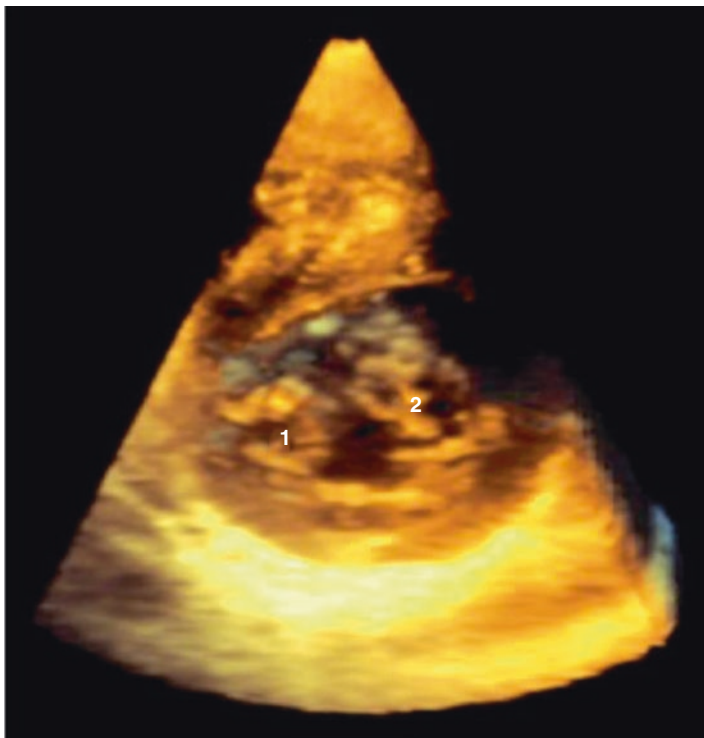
Parasternal short axis of 3D echocardiogram image from a patient with a transitional atrioventricular canal defect and a double-orifice left AV valve, with number marking each orifice, (used with permission from DeFaria Yeh D, King. Cardiovascular Imaging Repo (2013)6:454–466)
